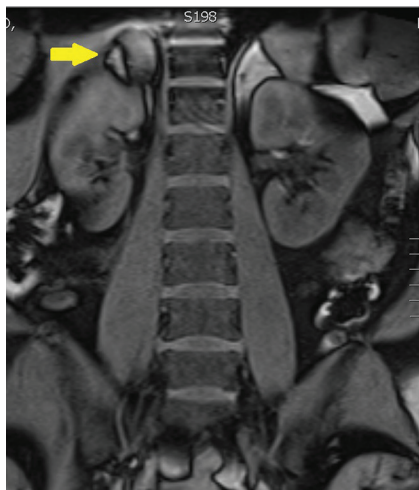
Abdominal Magnetic Resonance Imaging—Coronal View
